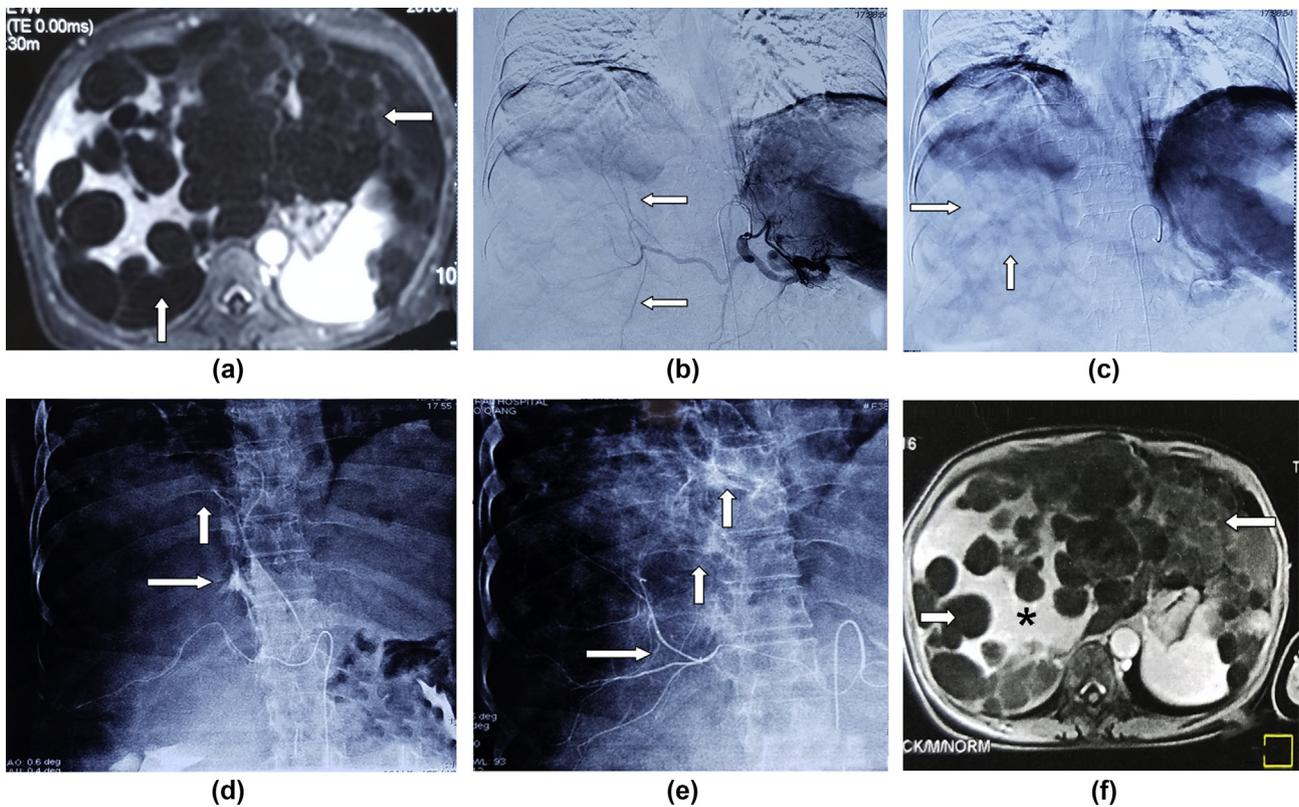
A 55-year-old female PLD patient presented with severe abdominal distention and loss of appetite. (a) Preprocedural portal phase MRI demonstrates obviously hepatomegaly and almost the entire liver lobe is replaced by multiple cysts (arrows). (b) Coeliac arterial angiography before TAE shows that the right hepatic arterial branches are stiff and stretched (arrows). (c) Indirect portal venography obtained at the late phase of superior mesenteric artery angiography shows that the portal vein branches in the cystic regions (arrows) are obstructed. (d,e) Fluoroscopy with spot film shows super-selective injection of the mixture of NBL in the inferior phrenic artery and hepatic artery branches supplying the cystic regions (arrows). (f) MRI image at the same level as in (a), obtained at 36 months after TAE, shows obviously reduction of the cysts (arrows), and the normal hepatic parenchyma is markedly expanded (asterisks).
